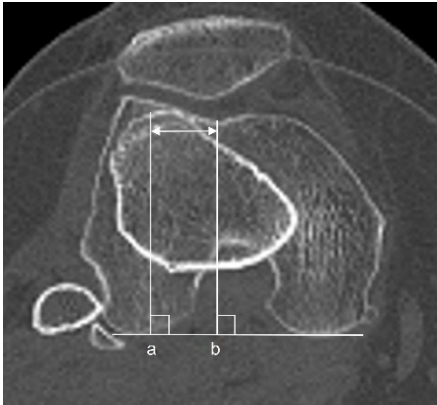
Radiographic assessments.
